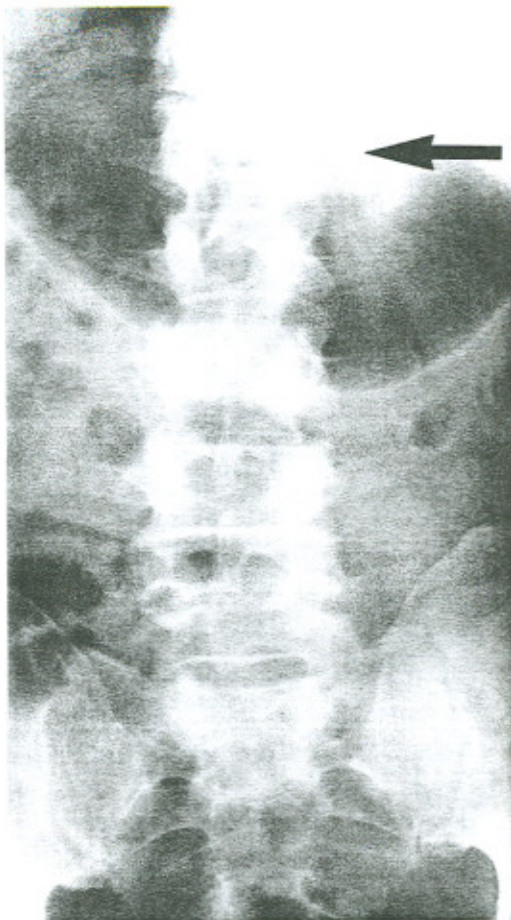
Anteroposterior (AP) and lateral radiographs taken at time of injury, originally reported as normal. The L1 vertebra is not visualized on the lateral view. Lateral wedging of the superior end plate of the L1 vertebra can be seen on the lateral view. Also notice the increase of the interpedicular distance at this level (arrow).
